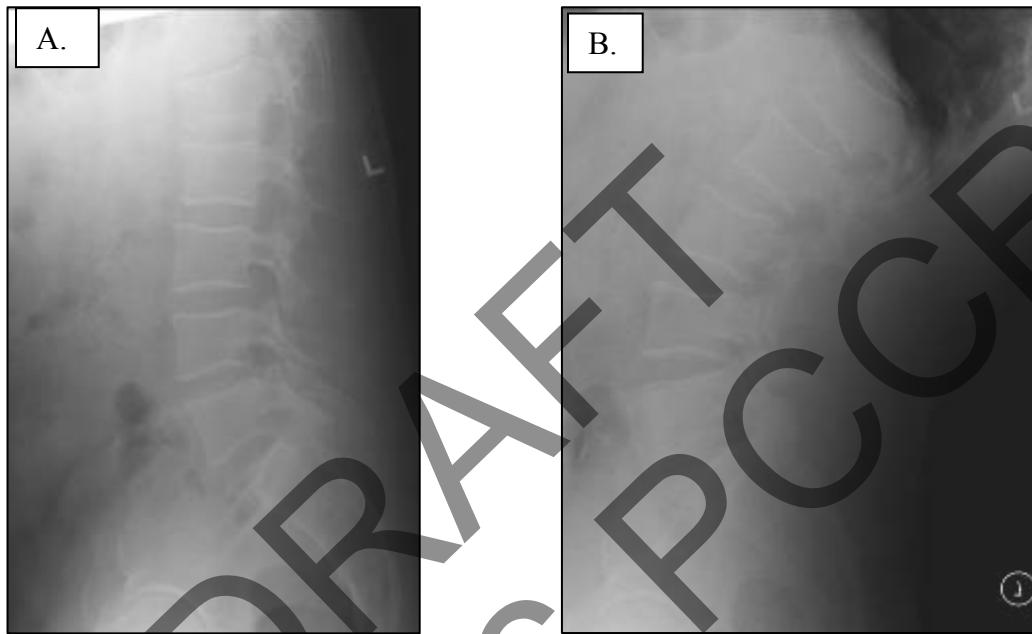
Lateral Lumbar Flexion and Extension Radiographs. The patient is positioned with the pelvis centered to the bucky. The central ray is aimed at the L3 level. The 14x17 cassette may have to be rotated 90° in order to have T12 appear on the film in flexible persons. In A, lumbar flexion is shown. In B, lumbar extension is shown. Note: the L1 compression fracture and the retrolisthesis apparent at L1 and slightly at L2.
